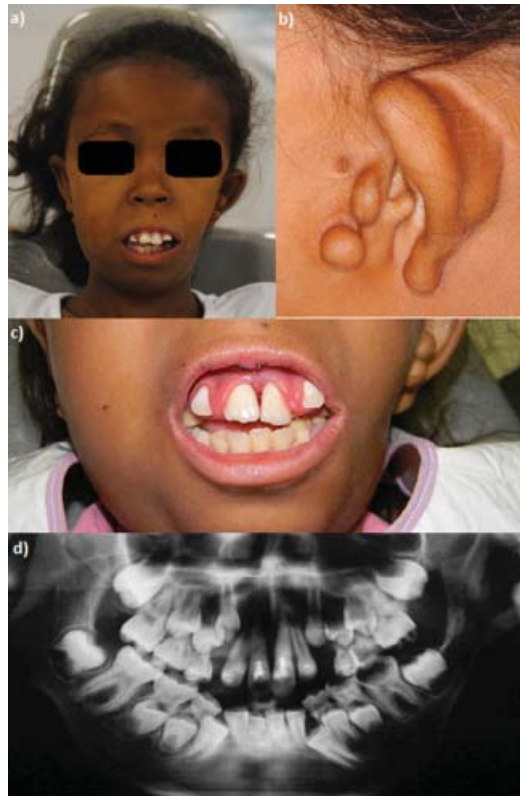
Clinical and radiographic findings: a) face asymmetry, low-set ears, preauricular tags, eyes slightly separated, epicanthal folds, down-turned corners of mouth, convex facial profile with mandibular microretrognathia, hypofunction of perioral musculature, cheeks, and tongue, and absence of lip seal; b) preauricular tags; c) vestibular projection of upper central incisors, which suffered lateral and extrusive luxation; d) panoramic radiograph obtained after the introduction of calcium hydroxide paste to stimulate apexification of immature teeth.
